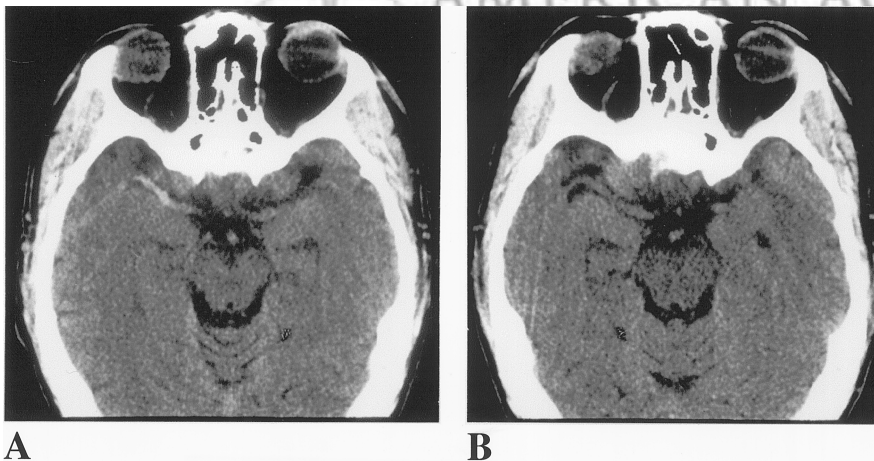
(A) Noncontrast axial CT performed 45 minutes after the onset of symptoms demonstrates a hyperdense right middle cerebral artery (MCA), with no evidence of intracranial hemorrhage. There was subtle asymmetry of the sylvian fissures, but no definite involvement of the right lentiform nucleus or insular ribbon (not shown). (B) Three-hour follow-up axial CT demonstrates resolution of the hyperdense right MCA.
